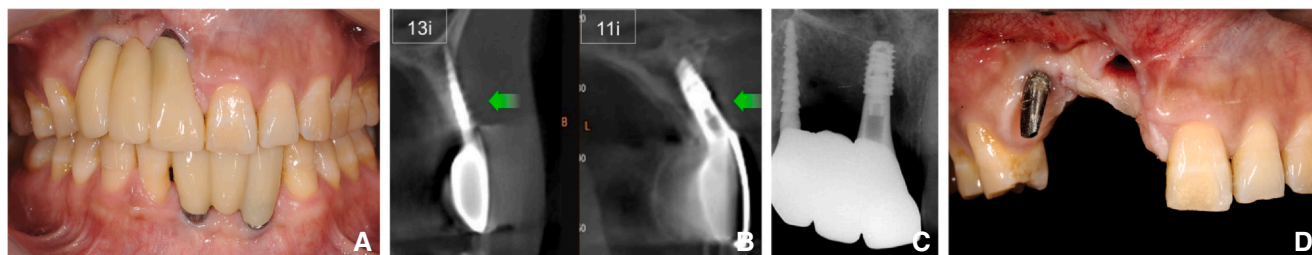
A, Initial situation presenting unesthetic fixed dental prosthesis in right maxillary anterior region. B, C, Cone beam computed tomography image and periapical radiograph present labial bone resorption (green arrow) and deepened implant position. D, Clinical view after prosthesis removal.
